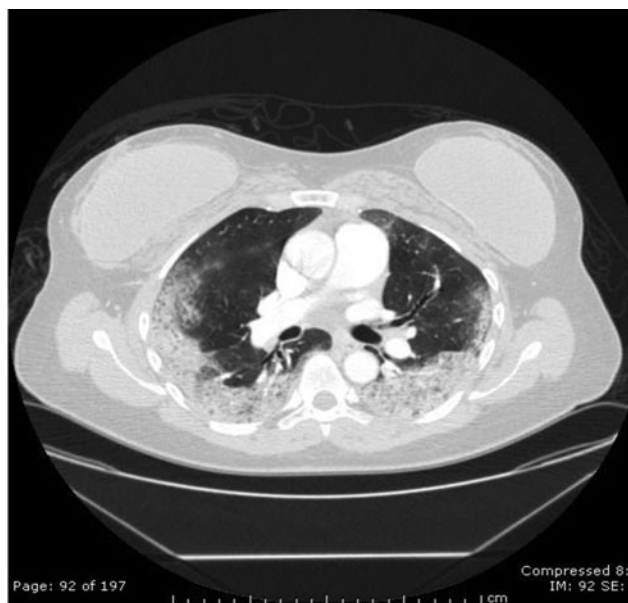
Computed tomography chest showing mixed interstitial and alveolar densities along the dependent and peripheral region of the lungs, with sparing of the central regions.
